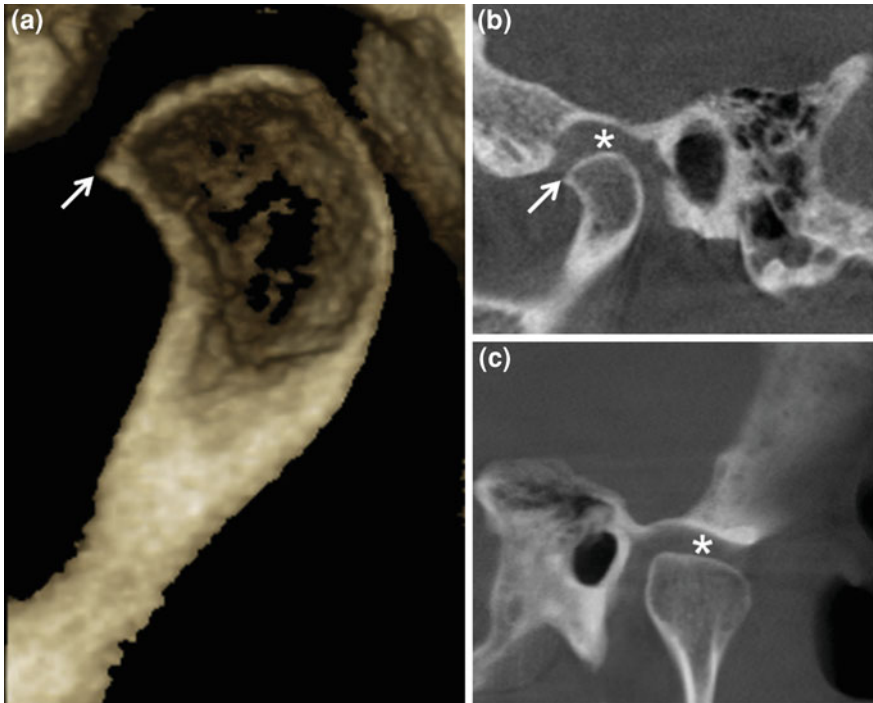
CBCT sagittal (b) and coronal (c) scans and 3D reconstruction (a) of left condylar head. The joint space (*) is not reduced, but we can note a small degenerative osteophyte (*thin arrow*) on the anterior surface of the condylar head
